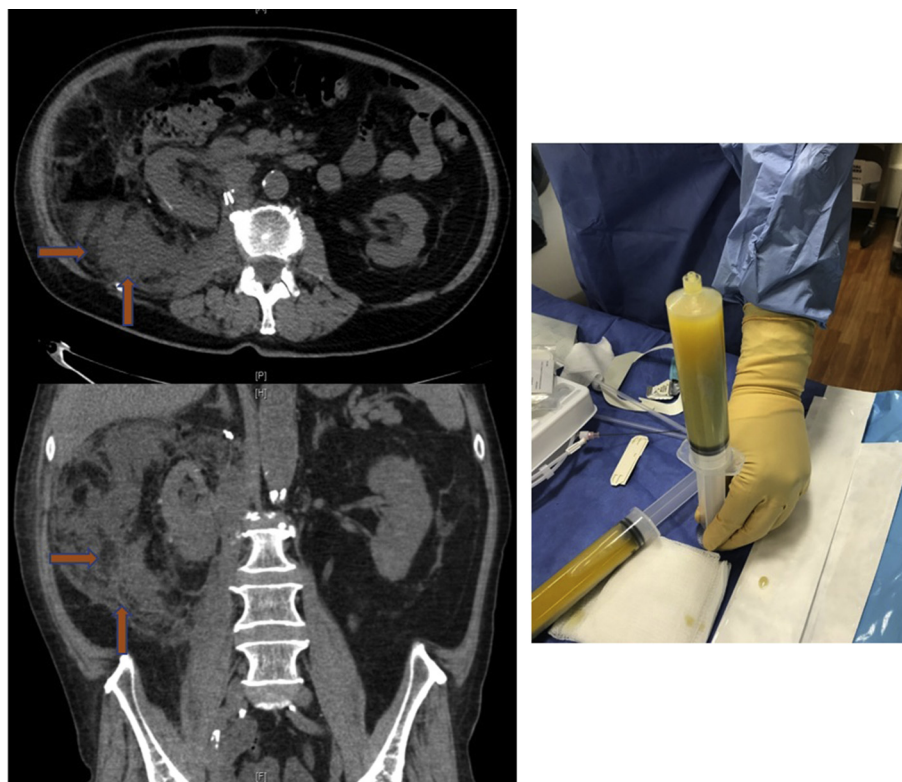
A—CT scan from 2nd admission. CT abdomen non contrast. Arrows indicated coalescing fat necrosis surrounding the right kidney. Top Axial view, Bottom Coronal view. 2B—Aspirated material from IR percutaneous drainage.
